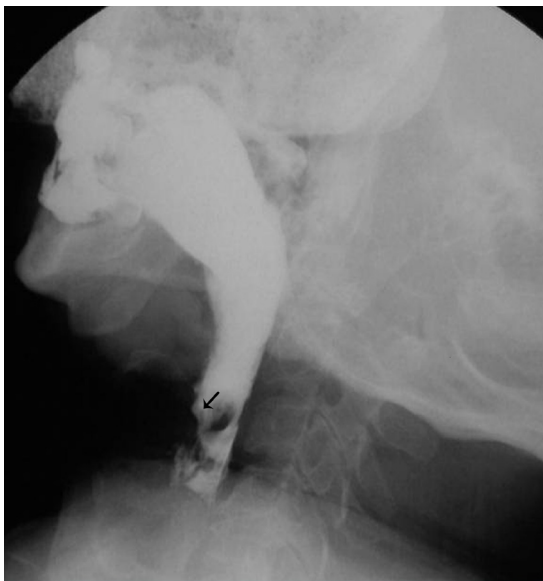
Barium swallow radiograph showing the compression on the anterior side of esophagus (black arrow).
